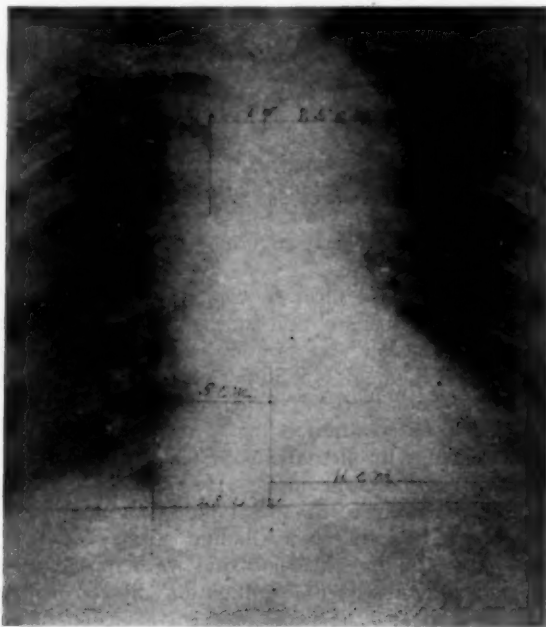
Roentgenogram of chest taken July 24, 1941, showing aneurysm.
